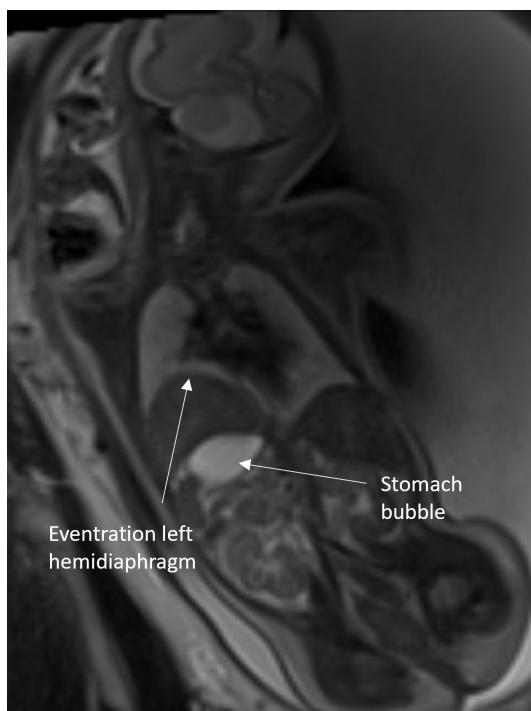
T2 HASTE Coronal MRI image of eventration of left hemidiaphragm in 35 week fetus
